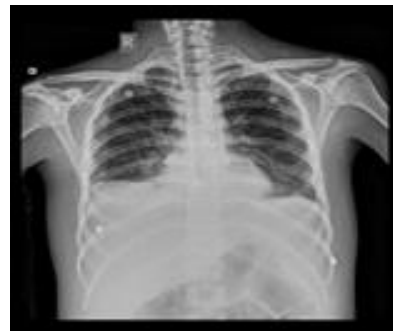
Chest radiograph demonstrates bilateral diffuse perihilar and basal air-space opacities with mild bilateral pleural effusion.
